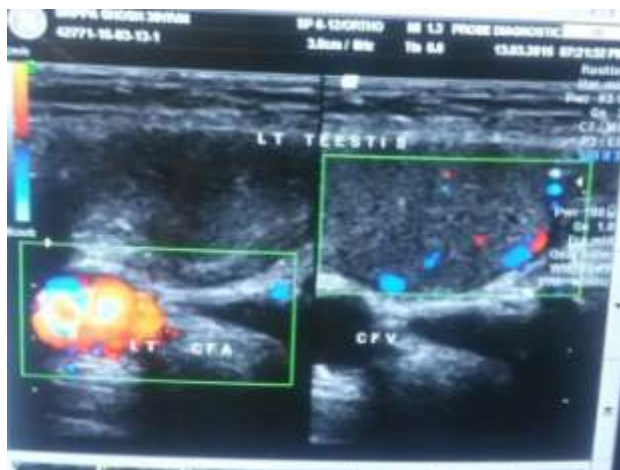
Ultrasound abdomen with colour Doppler showing intra abdominal left testes
